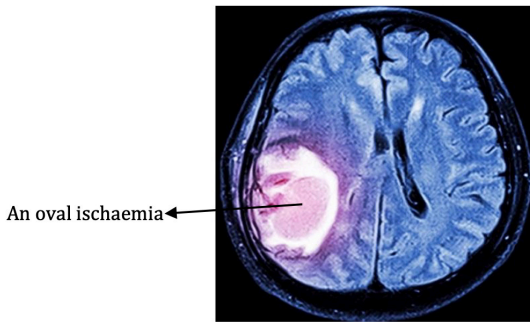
MRI axial image demonstrates oval hyperintense cerebral infarct in patients with stroke
